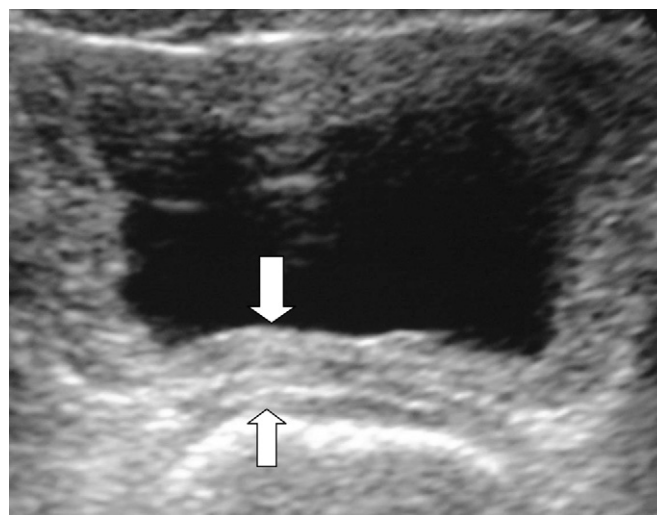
Transverse ultrasonography of the bladder demonstrating posterior wall thickening (arrows).
